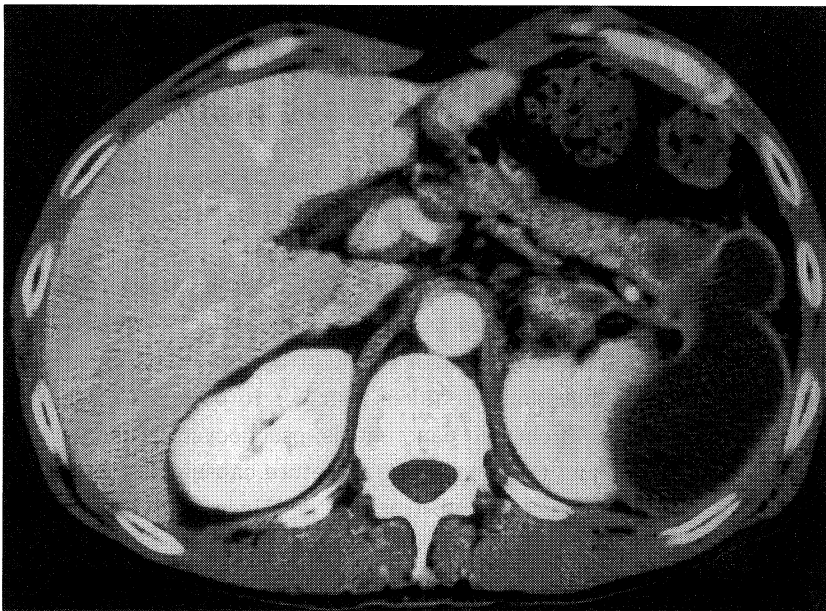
A computed tomographic (CT) scan of the abdomen revealed a pancreatic pseudocyst located in the pancreatic tail.
